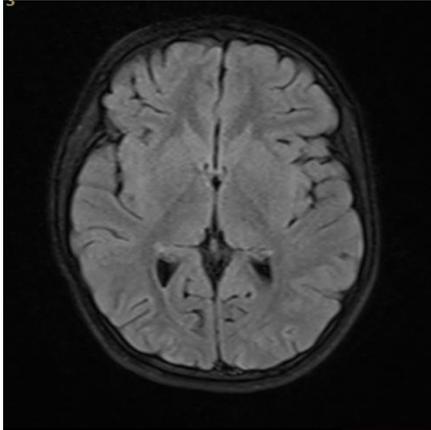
CEMRI brain revealed T2/FLAIR hyperintensities in subcortical regions of bilateral parieto-occipital lobes.
